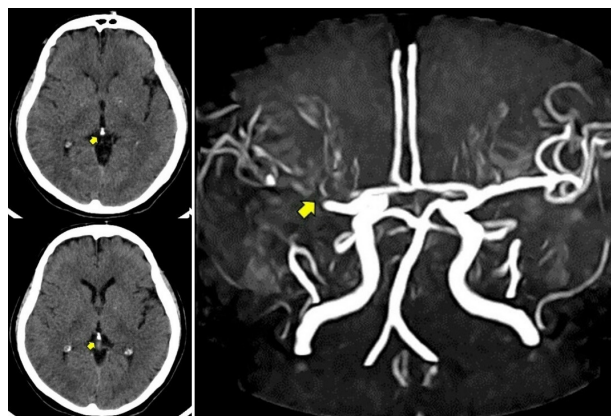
Left panel:* Unenhanced CT of the head showing moderate-to-severe pineal gland calcification (arrows). *Right panel:* Time-of-flight magnetic resonance angiography of intracranial arteries showing significant asymptomatic stenosis of the right middle cerebral artery (arrow).
